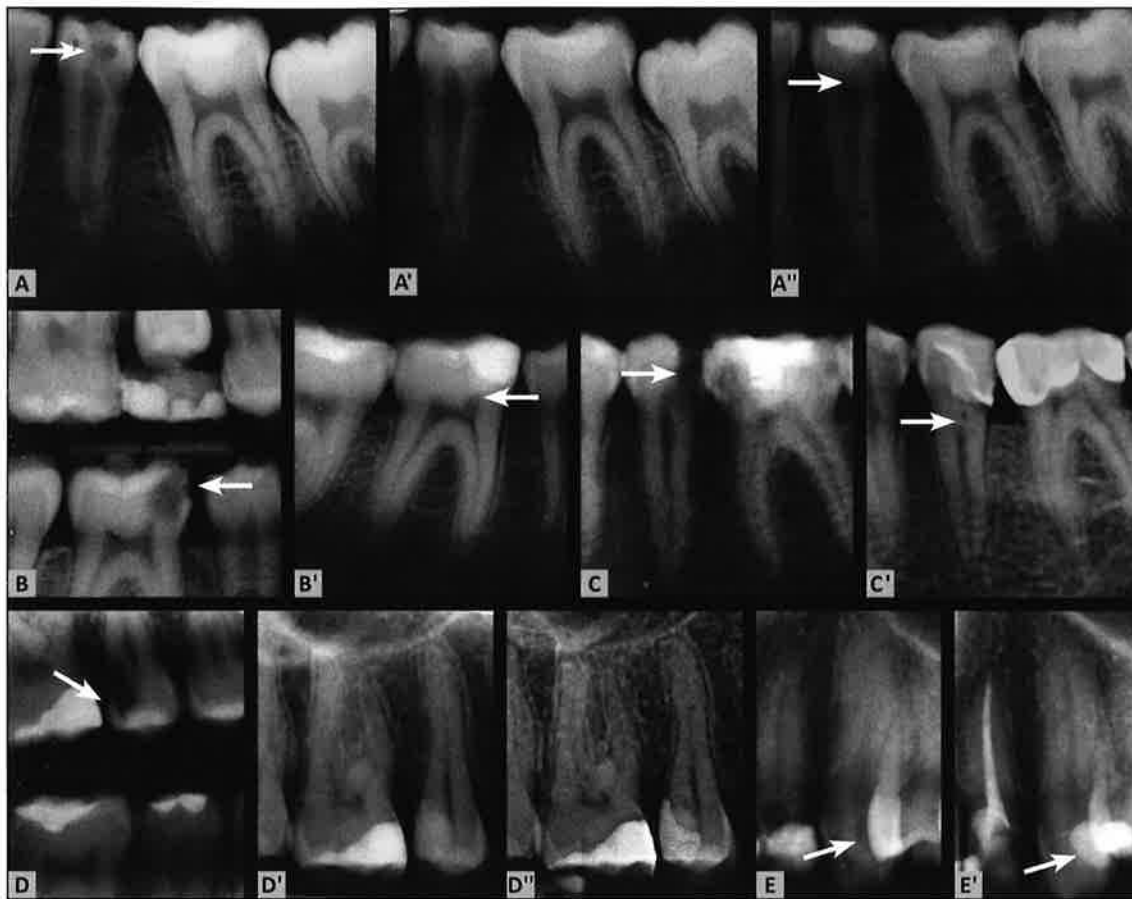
(A) The preoperative periapical radiograph shows a deep carious lesion in the second mandibular premolar (arrow). (A') Postoperative radiograph taken directly after the application of Biodentine for pulp capping and for temporary restoration. (A'') Follow-up radiograph after 18 months. There is dentine bridge formation and the development of the tooth (arrow). (B) The bitewing radiograph shows a deep carious lesion on the first mandibular molar (arrow). (B') The periapical radiograph after 18 months after direct capping does not show any pathological findings on tooth 46. There is dentine bridge formation (arrow). (C) The preoperative radiograph of the mandibular premolar shows a deep
